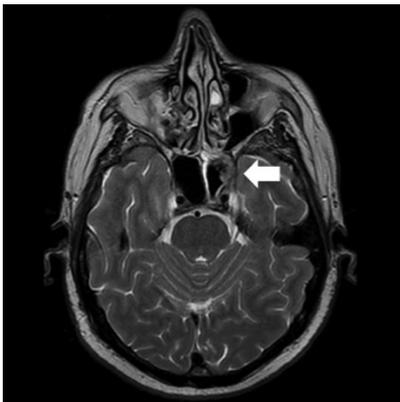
Magnetic resonance image, T2 weighted, axial view, with intravenous contrast enhancement. Hypointense signal is seen in the left sphenoid sinus with abnormal enhancement and thickening along the foramen rotundum and medial left middle cranial fossa (arrow).
